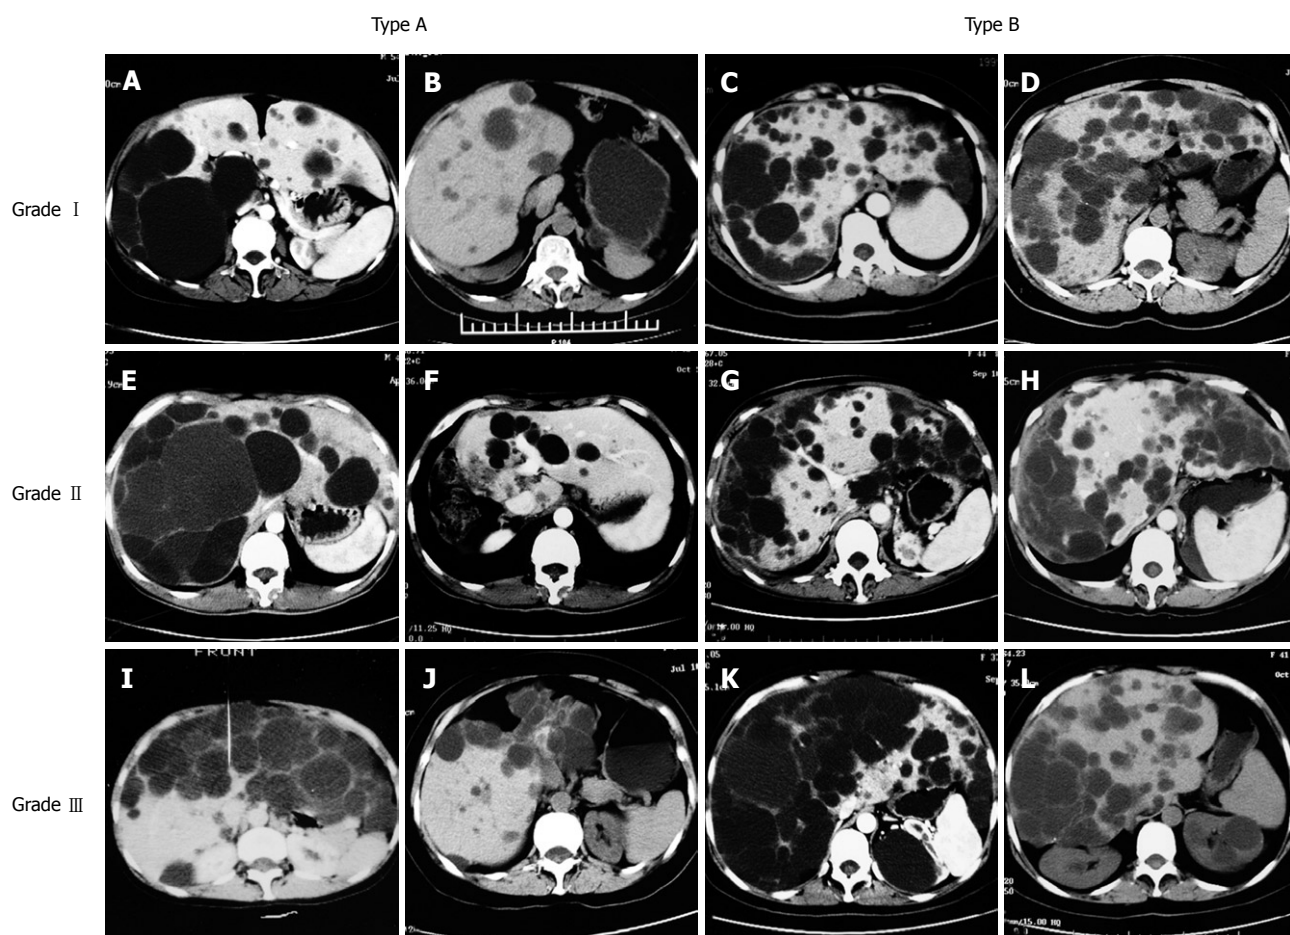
CT examinations of our classification of APLD. A and B: Type A-I, preoperative and postoperative CT examinations; C and D: Type B-I, preoperative and postoperative CT examinations; E and F: Type A-II, preoperative and postoperative CT examinations; G and H: Type B-II, preoperative and postoperative CT examinations; I and J: Type A-III, preoperative and postoperative CT examinations; K and L: Type B-III, preoperative and postoperative CT examinations.
